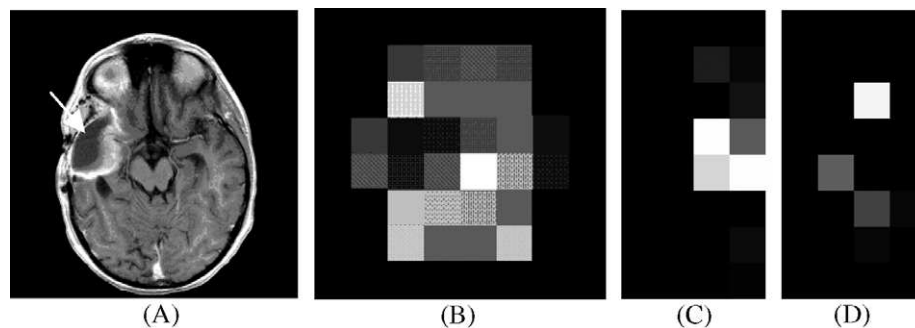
(A) T2 MR image. (B) FD results for the whole MR image with an 8×8 FD subimage matrix. (C) 8×4 negative FD difference matrix for the right-half MR image. (D) 8×4 positive FD difference matrix for the right-half MR image.
